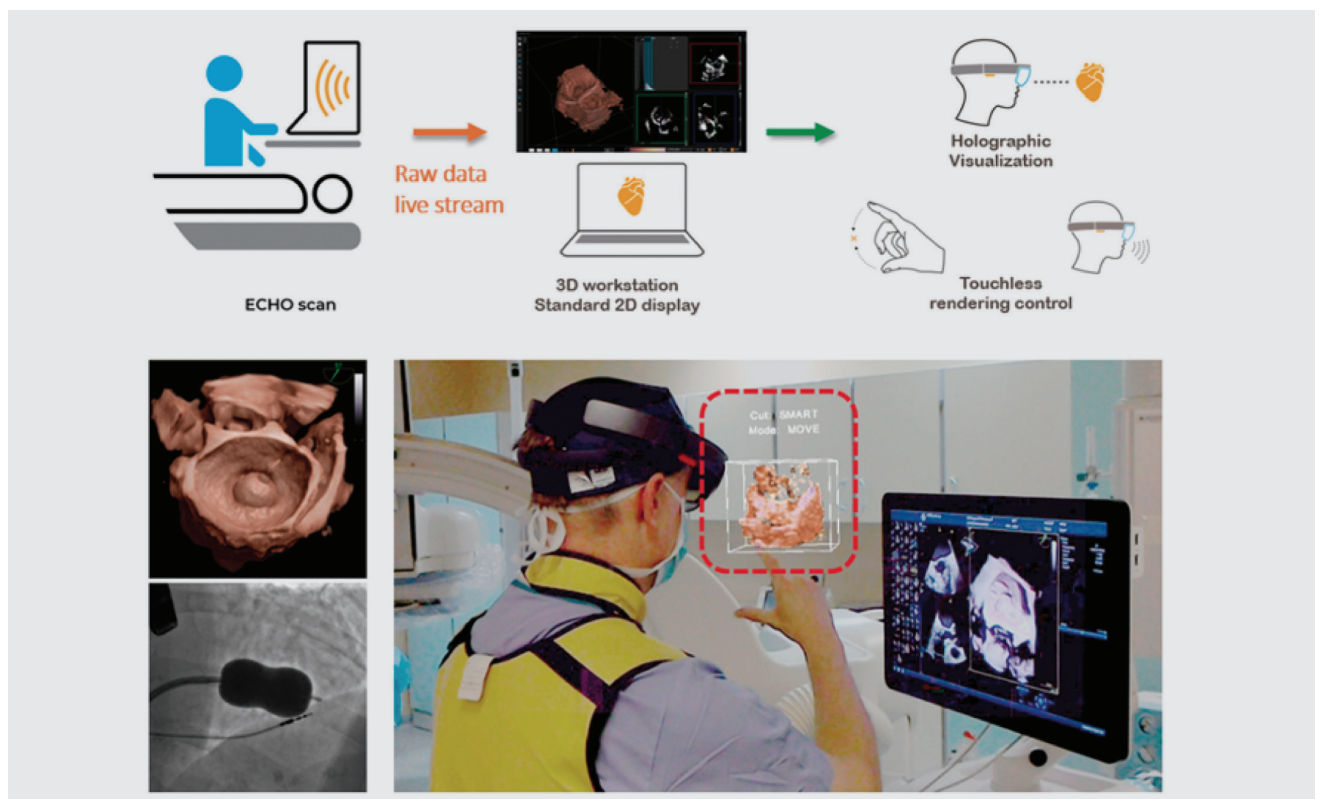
Graphical Abstract - Raw 3D data were streamed from standard echocardiograph using custom connection to 3D DICOM viewer workstation (CarnaLife Holo, MedApp, Krakow, Poland) for real-time, dynamic 3D rendering and wirelessly transferred into HoloLens mixed reality display (Microsoft, Redmond, USA) to overlay non-obstructive 3D data hologram upon reality view. Data were visible as a semitransparent holographic cube positioned in a convenient sector of visual field of echocardiographer and shared by interventional cardiologist. Reproduced with permission from Kasprzak et al.⁷
